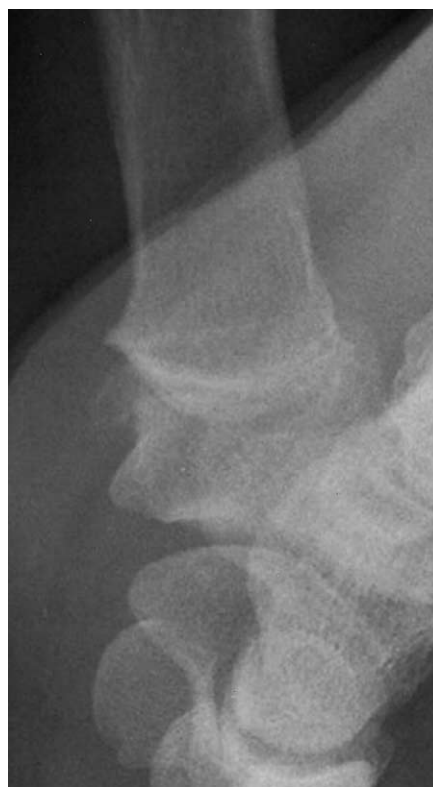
Preoperative radiographic study showing marginal osteophyte and bone-to-bone contact in stage III osteoarthritis.
